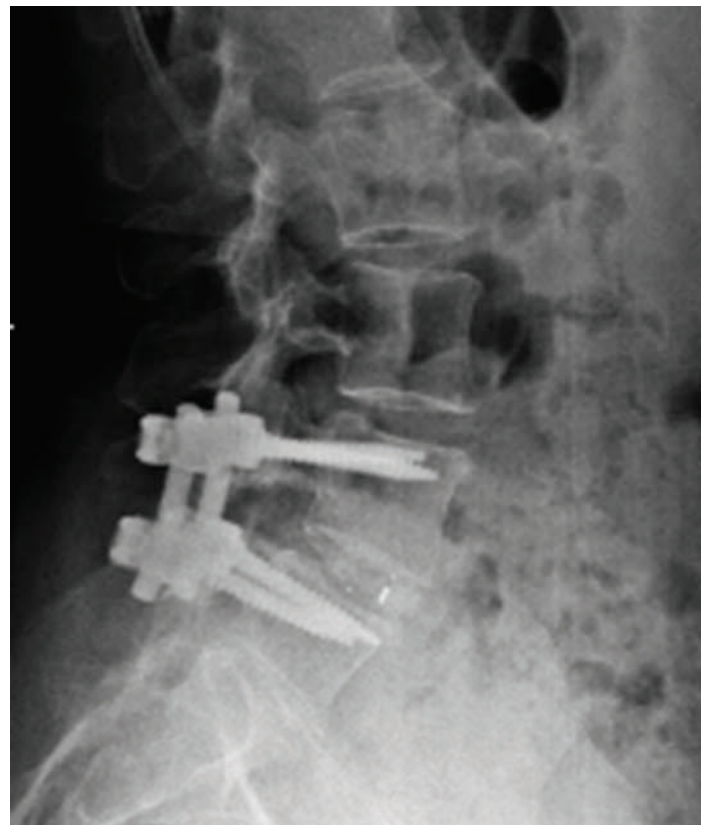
Lateral view of postoperative x-rays following a fusion at the L4-L5 level.
